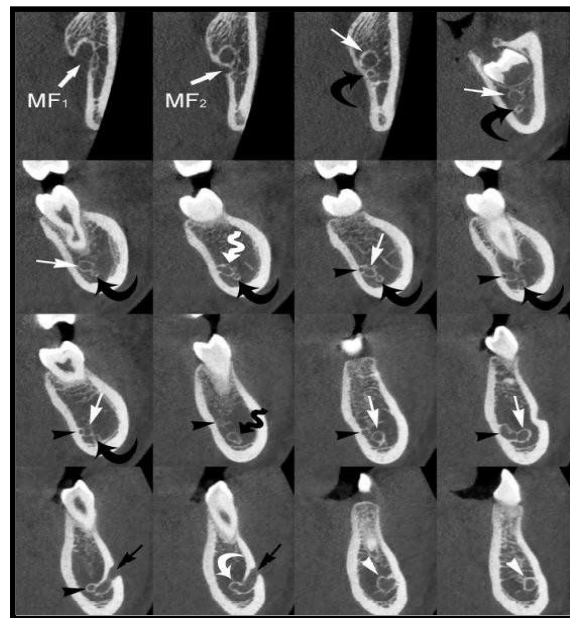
Cross-sectional CBCT images show the buccolingual position of the three MC (MCmain, AMC1, AMC2).
